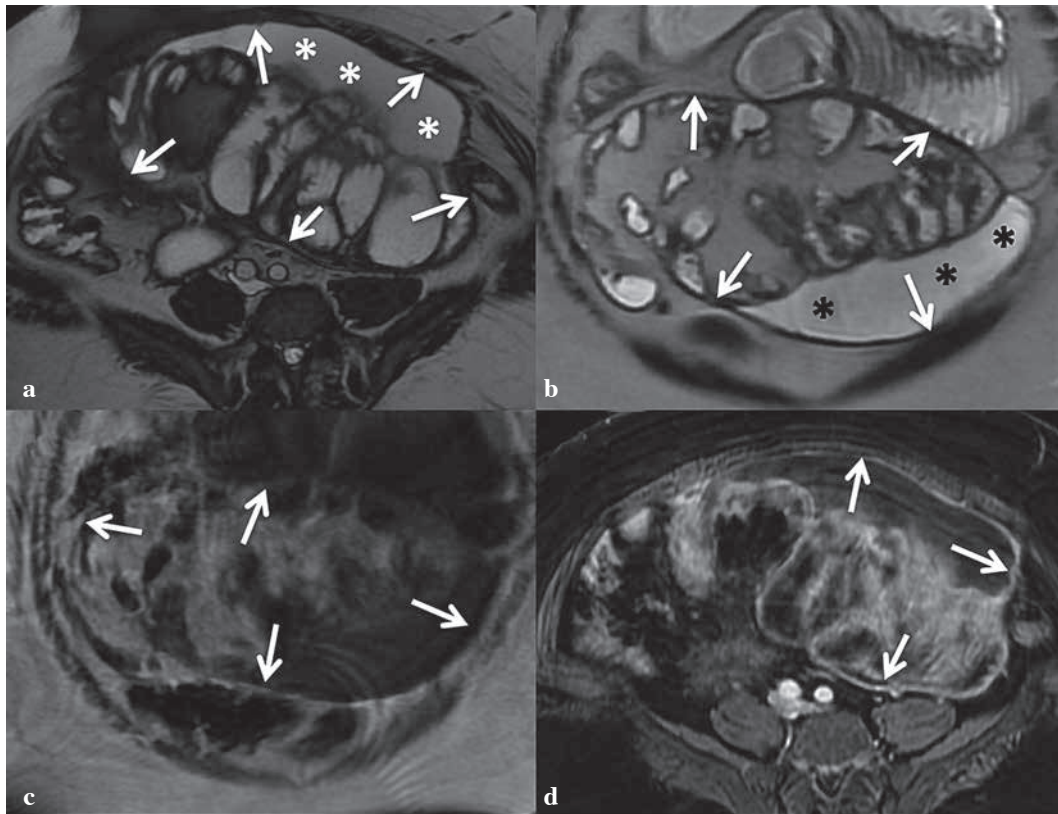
Axial FIESTA (a) and coronal (b) T2 weighted MRI of the same patient displayed the hypointense fibrous sac (arrows) and free intraabdominal fluid (asterisks) clearly. The fibrous sac (arrows) was hypointense on coronal T1 weighted MRI (c), enhanced after IV contrast agent administration on fat suppressed T1 weighted MRI (d).
